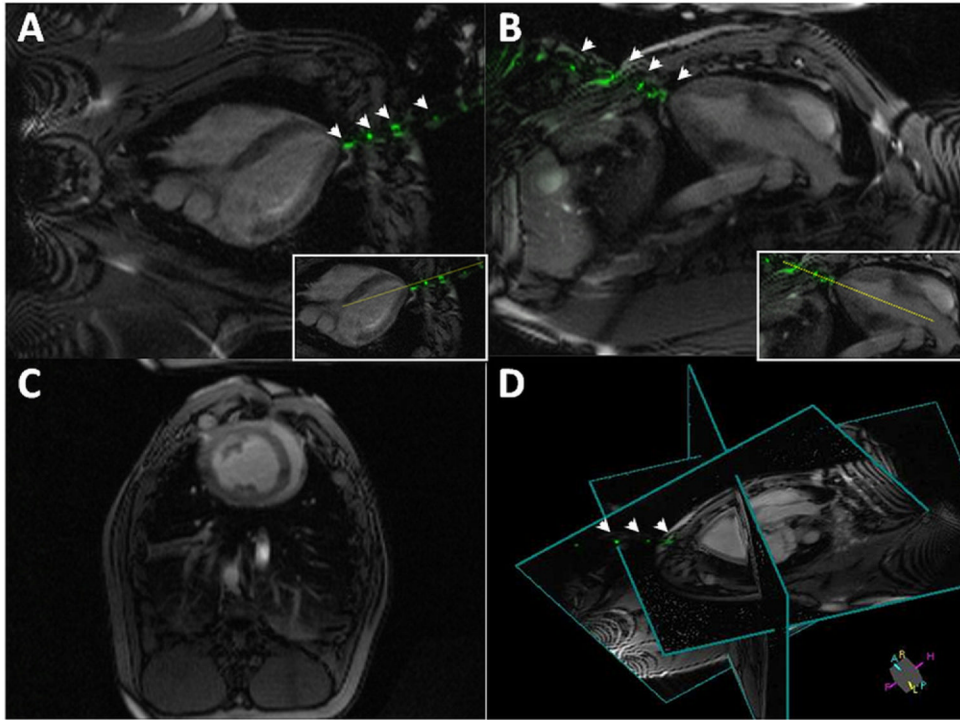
Real-Time MRI During LV Access
